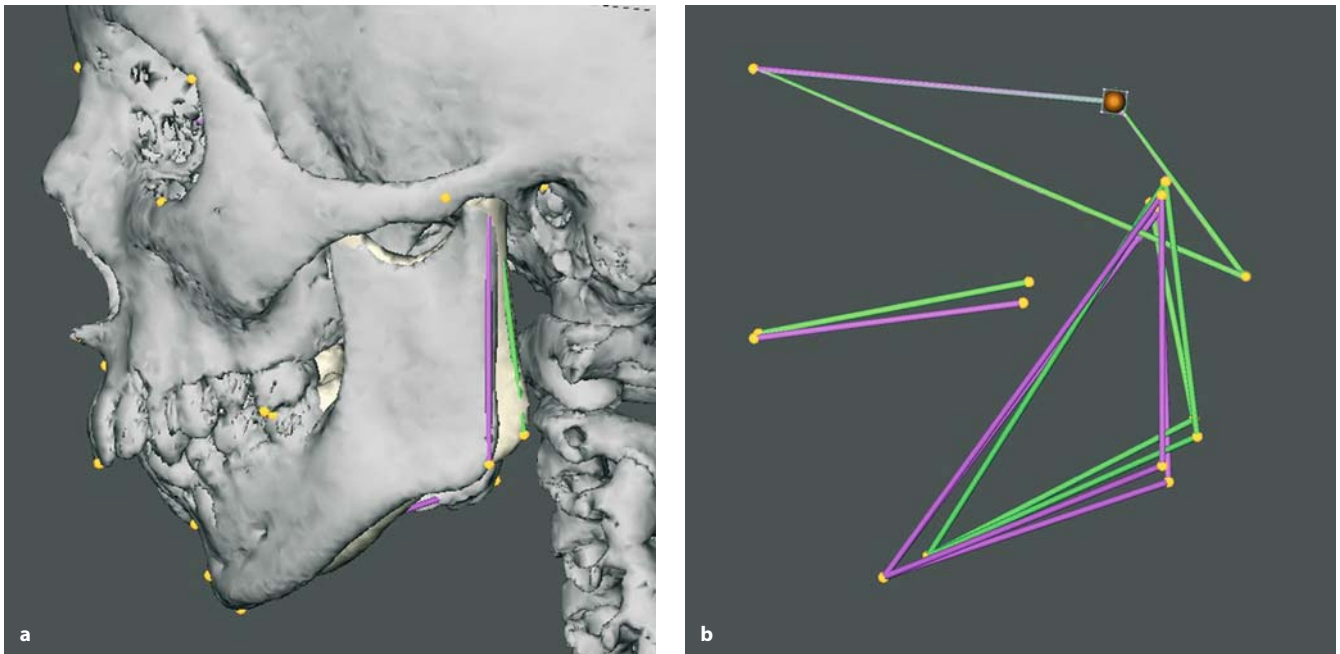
Superimposition of pre-operative (*green*) and post-distraction (*purple*) 3-D CT hard tissue surface representations (a) and 3-D cephalometric tracings (b) using the 3-D cephalometric reference system. Note the improvement in chin projection and increase of anterior and posterior facial height. Profile view left. (3-D CT, patient B.R.)
